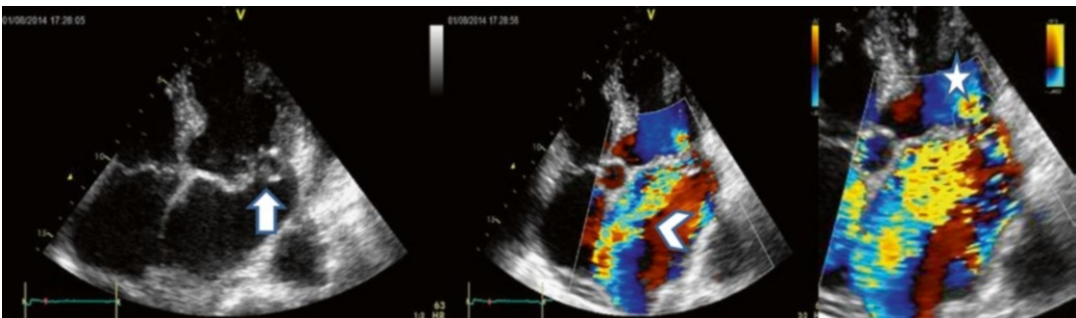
Echocardiography, four-chamber view. From left to right: two-dimensional imaging shows thickened mitral leaflet with posterior leaflet prolapse (*arrow*). Color Doppler shows severe eccentric mitral regurgitation
